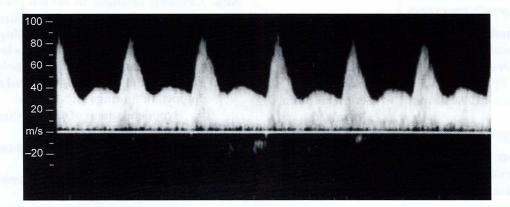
Flow velocity waveform (Doppler velocimetry) of the uterine artery at 26 weeks of gestation. This shows early diastole 'notch'. Presence of this notch and elevated resistive index (RI) or pulsatility index (PI) at advanced weeks of gestation indicate high uterine vascular resistance and reduced placental blood flow. This is thought to be due to failure of trophoblastic invasion of the spiral arteries.
